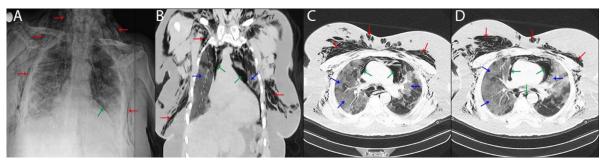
Radiological findings of Case 1. The posteroanterior chest radiograph (A) showed PM (green arrow), and subcutaneous emphysema (red arrow) into the neck. A coronal (B) and axial (C and D) chest CT scans revealed subcutaneous emphysema (red arrow), diffuse PM (green arrow), bilateral diffuse areas of ground-glass opacity, and consolidations (blue arrow).
